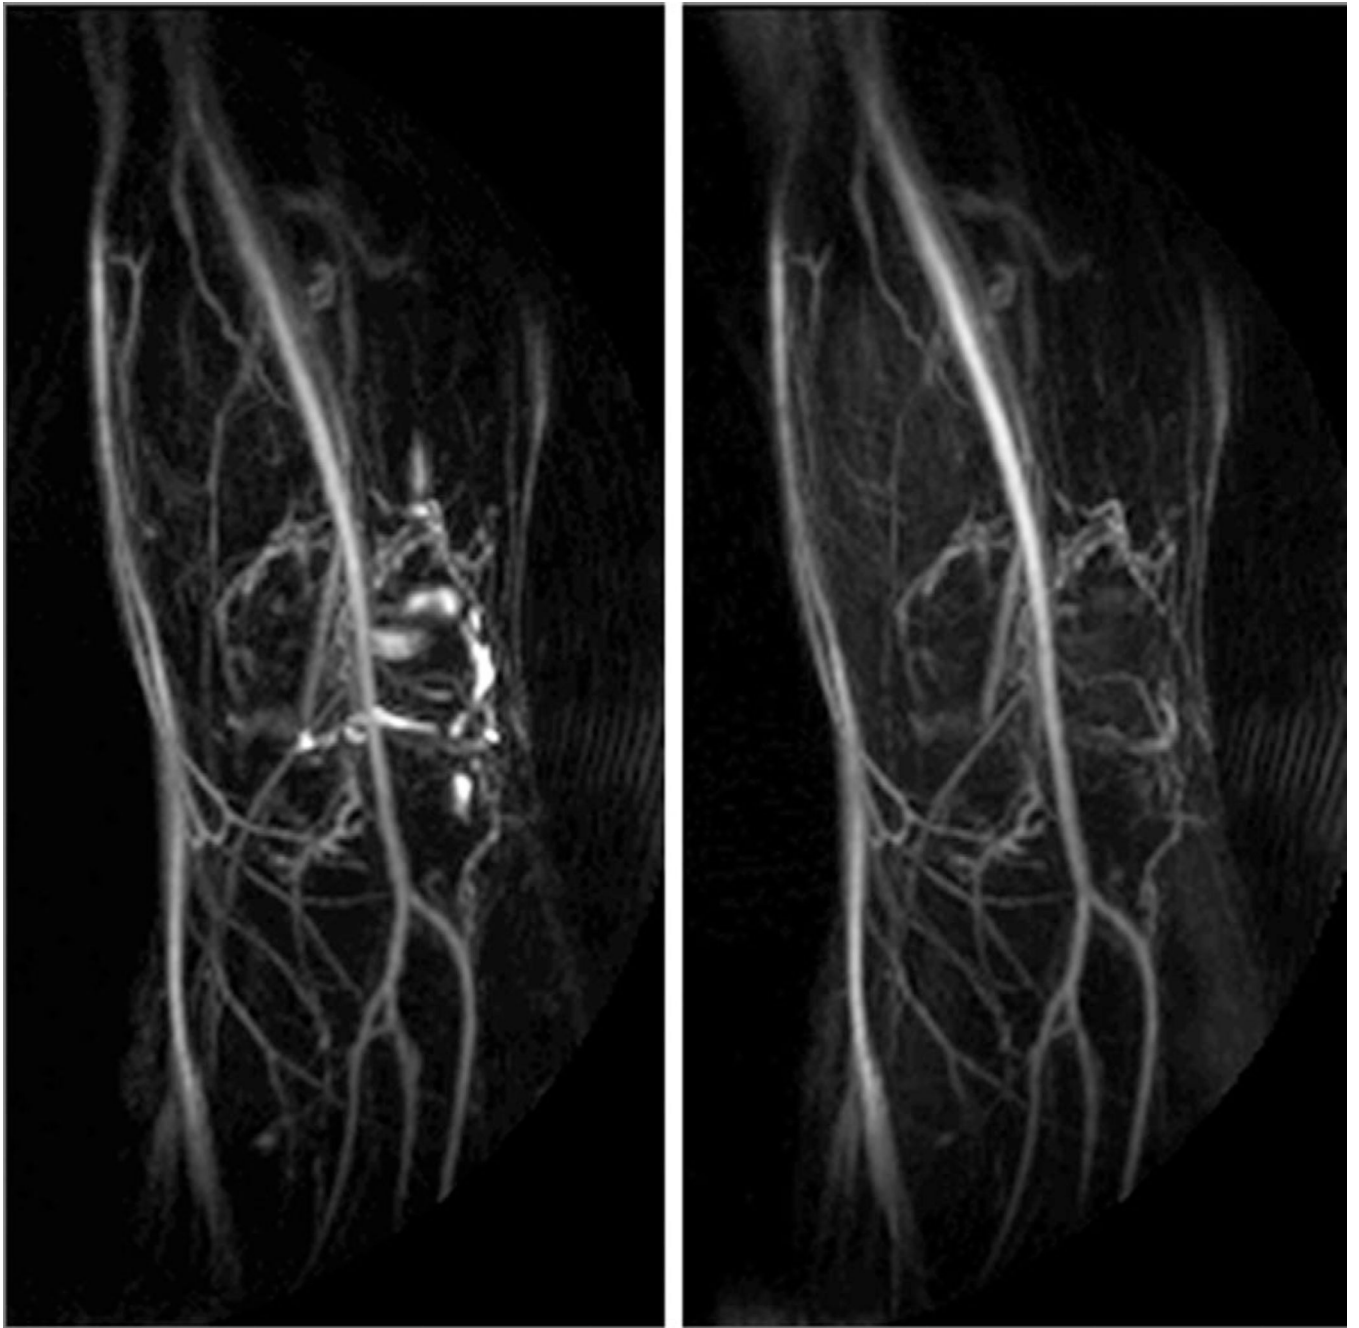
Left: No IR prep. Right: IR prep (FLAIR). Synovial fluid in the knee may be suppressed with the addition of an appropriately timed IR pulse, at the expense of signal and contrast.
